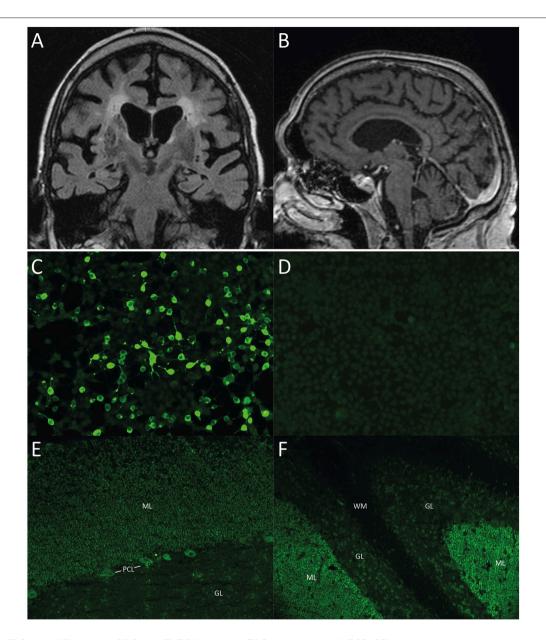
(A, B) Cerebral MRI of case 1. (A) Coronal T2 TIRM image and (B) Contrast-enhanced MPGRAGE image showing whole brain atrophy apparent in the frontal and parietal cortex as well as in the insular region with proportional atrophy of the hippocampus and the cerebellum as well as signs of microangiopathy.
